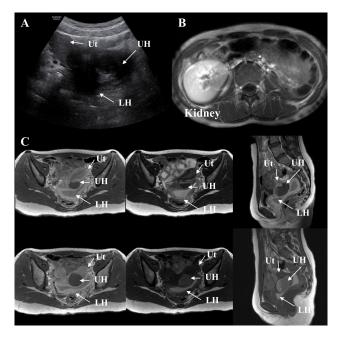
Image findings. (A) Sonographic finding. Left-side uterus and double hematocolpos are shown. (B) MRI finding. The single right kidney is shown. No other urinary tract abnormalities except the ipsilateral renal agenesis were noted. (C) MRI finding. A double uterus, double cervix and two vaginal pouches are shown. The upper vaginal pouch containing an old hematoma connected with the left-side uterus about 4.9×3.3 cm in size. The lower vaginal pouch containing a subacute stage hematoma is wrapping the upper vaginal pouch. Ut, uterus; UH, upper hematocolpos; LH, lower hematocolpos; HWW, Herlyn-Werner-Wunderlich.
